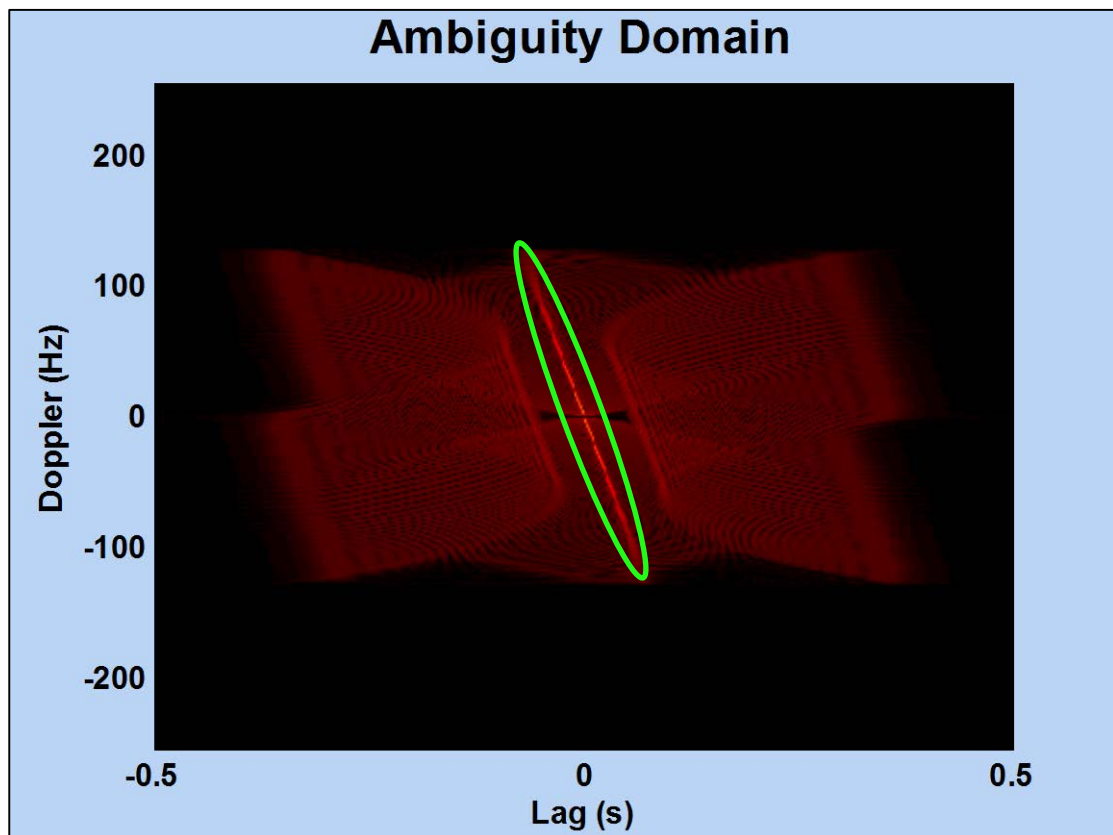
Doppler-lag or Ambiguity domain of the signal depicted in Figure A.3
